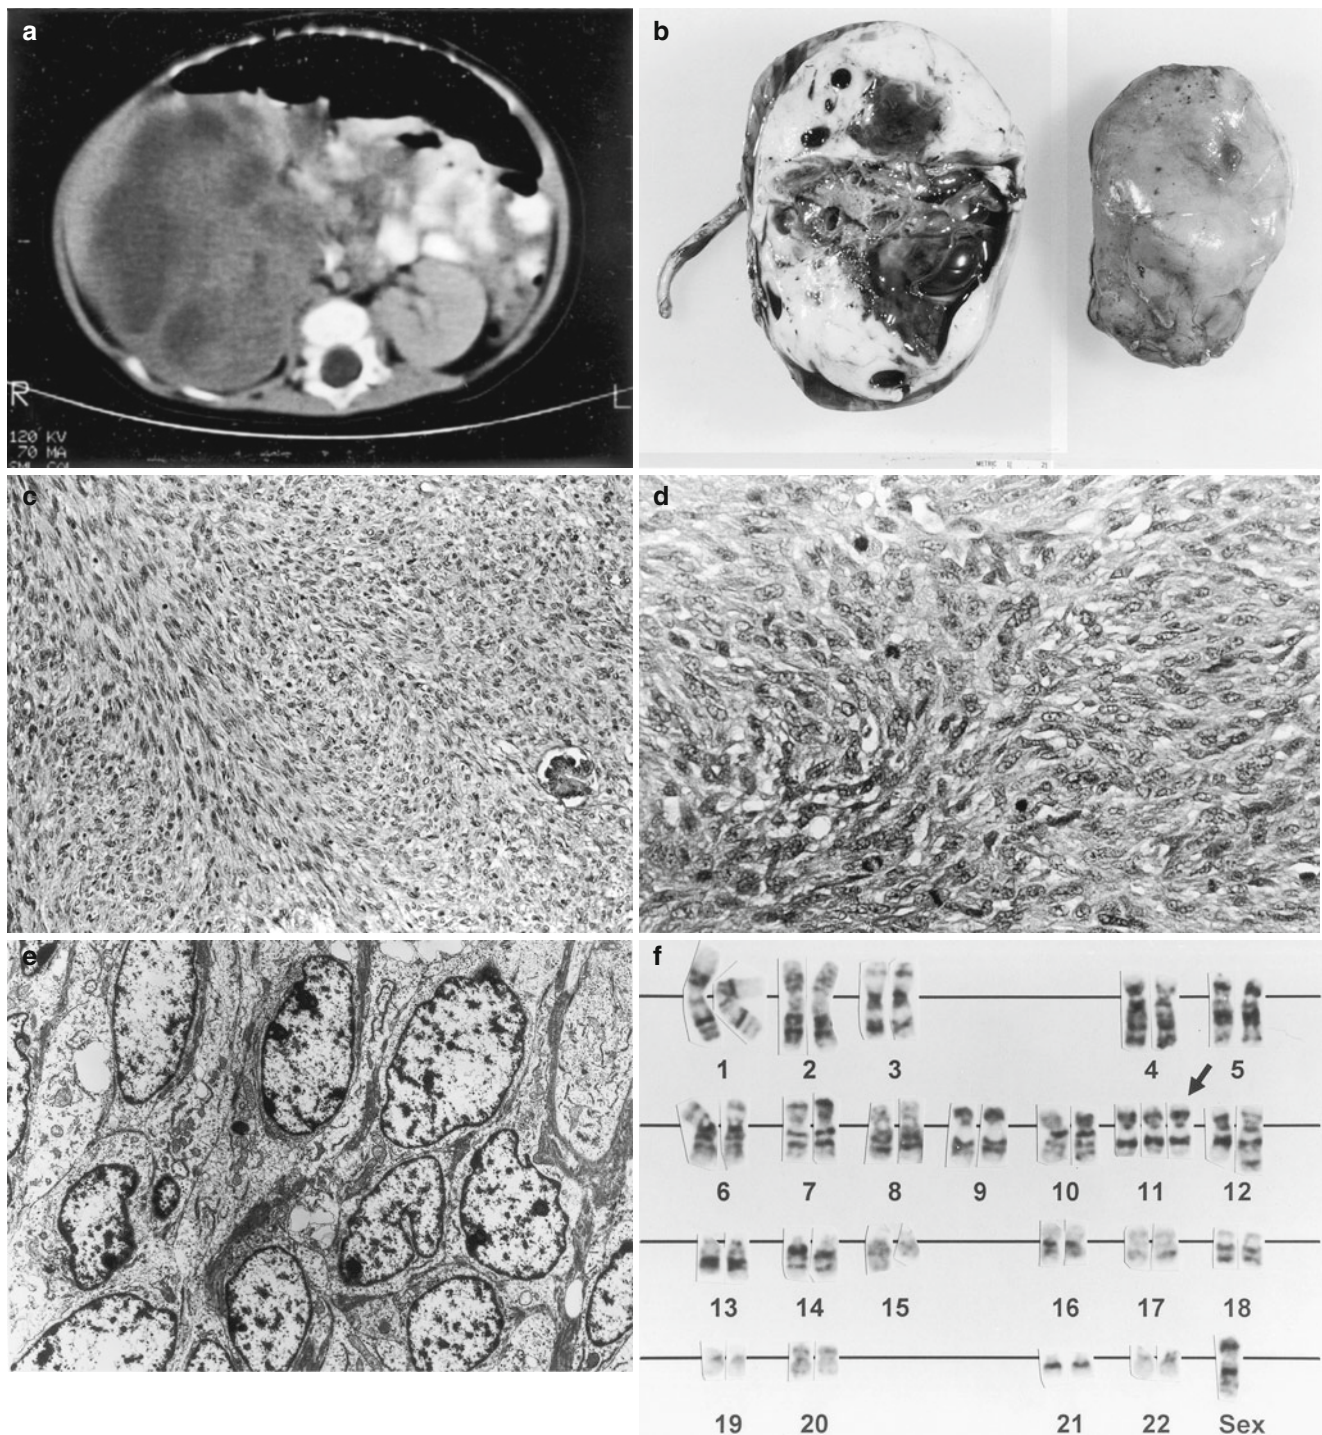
Cellular congenital mesoblastic nephroma. (a) CT scan of a 4-month-old female with an abdominal mass revealing a large right renal lesion composed of both solid and cystic areas. (b) The right kidney, 254 g and 10×8 cm, is replaced by a soft, light tan-gray tumor with a prominent cystic component. In contrast to the “classic” congenital mesoblastic nephroma described above, this tumor is encapsulated, circumscribed, cystic, and hemorrhagic. (c) Spindle-shaped cells with plump oval or fusiform nuclei are separated by a slightly vacuolated fibrillary stroma. It displays an interdigitating (“herring bone”) growth pattern. (d) The tumor is more cellular than the “classical” mesoblastic
